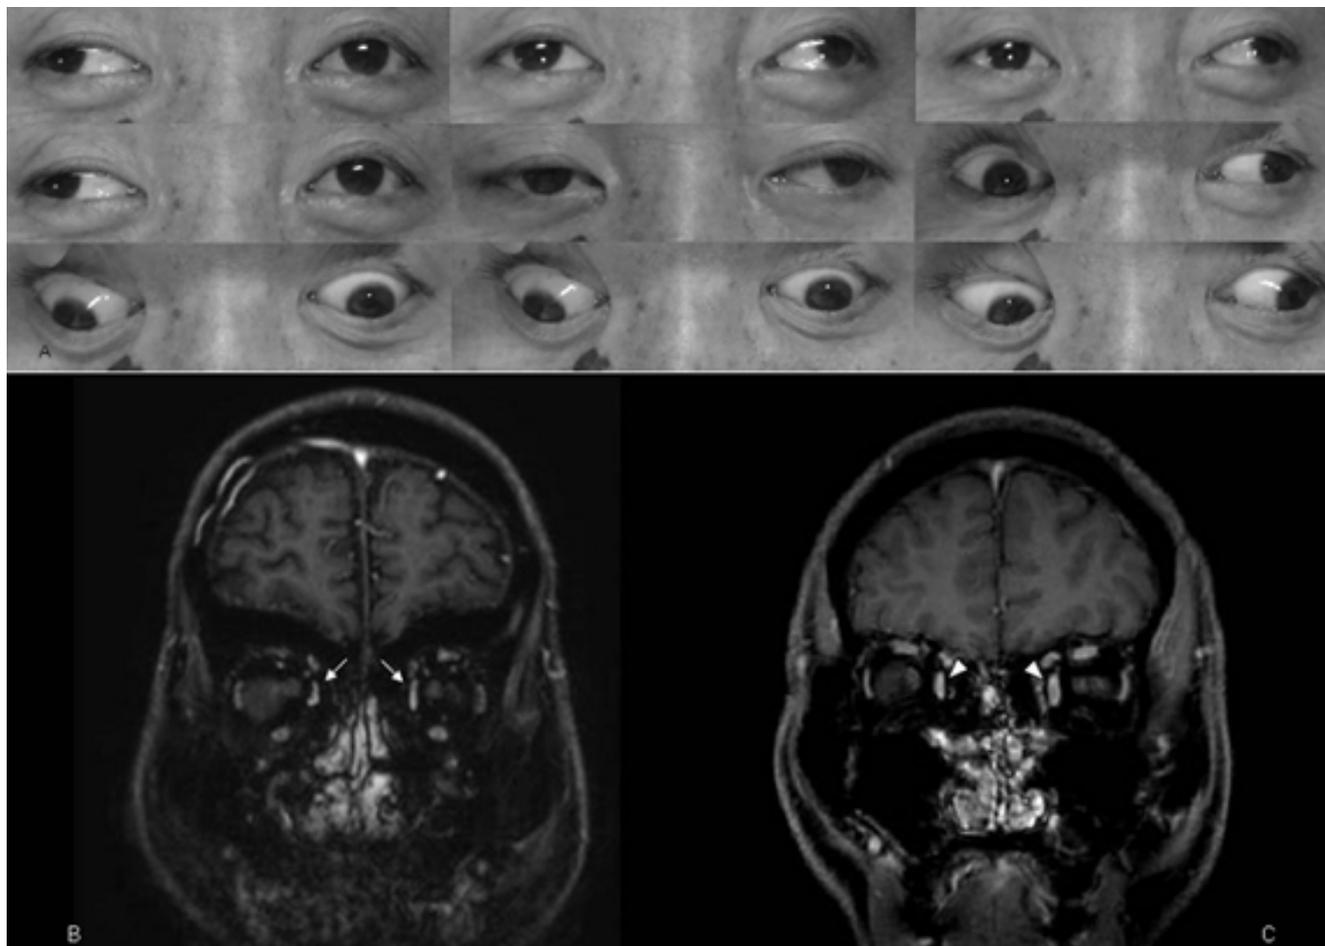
Ocular motor examination of patient shows limitation of adduction gaze bilaterally (A). Brain T1-weighted coronal MRI in (B) myotonic dystrophy patient and (C) age-matched healthy control subject. MRI shows the small and thin extraocular muscles bilaterally comparing with healthy subject (arrow head), especially prominent in medial rectus muscles (arrow).
